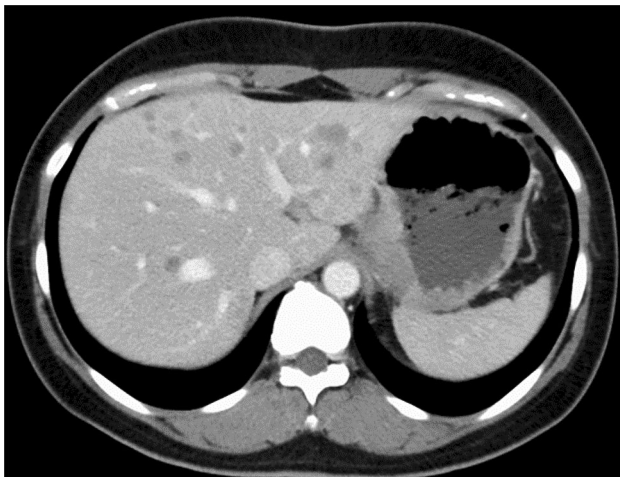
Computed tomography of the female patient
